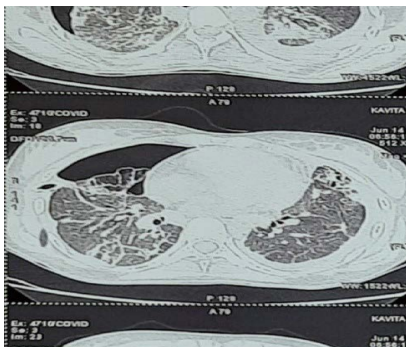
Her HRCT shows Rt-sided Pneumothorax with ICD in situ. Bilateral fibrotic changes
